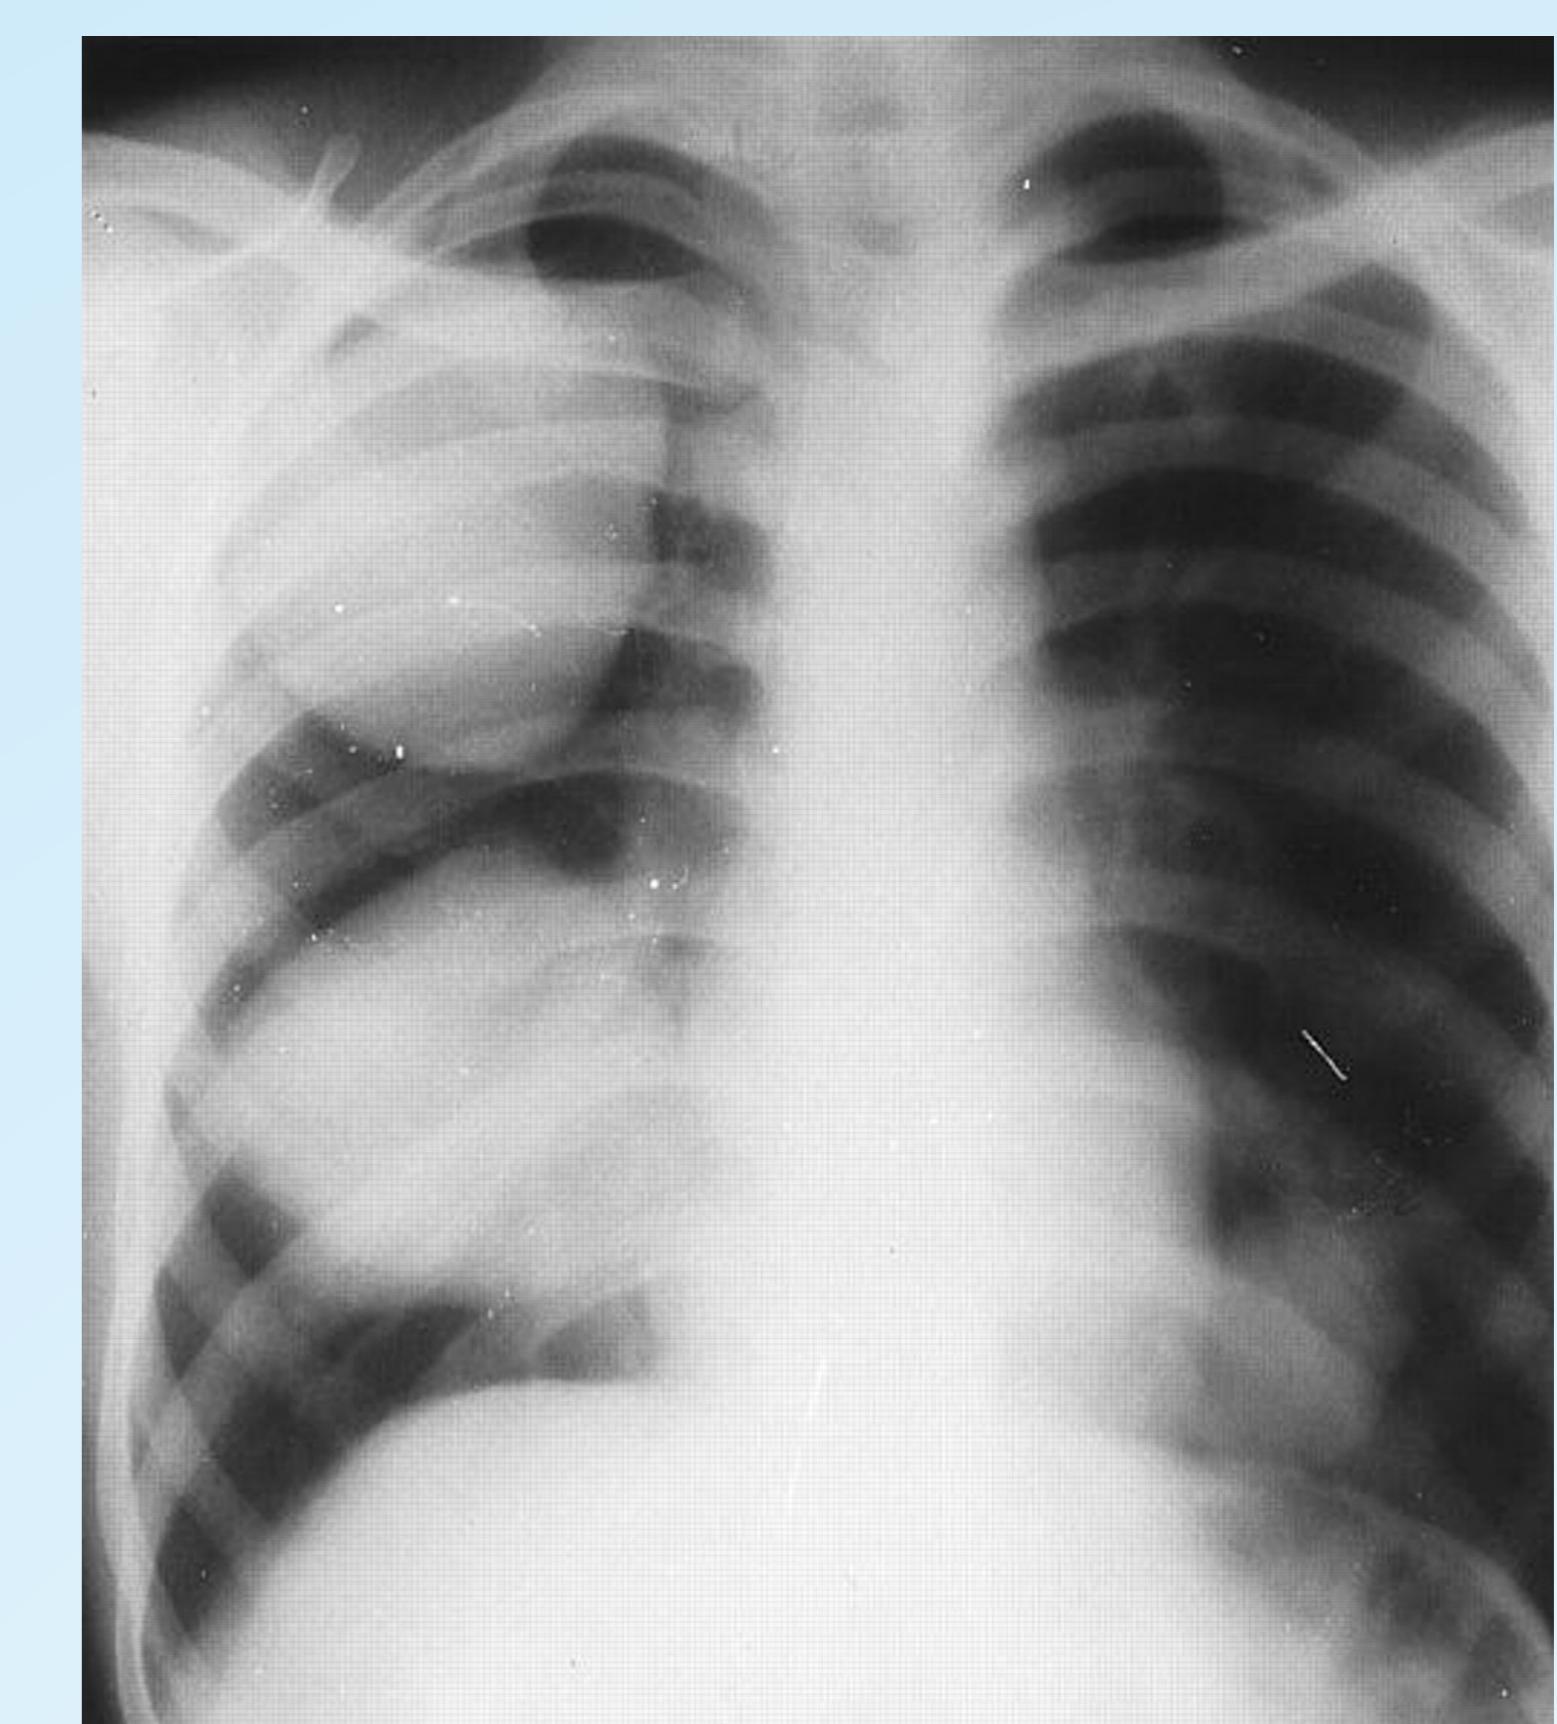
AP radiograph: multiple pulmonary hydatid cysts.
